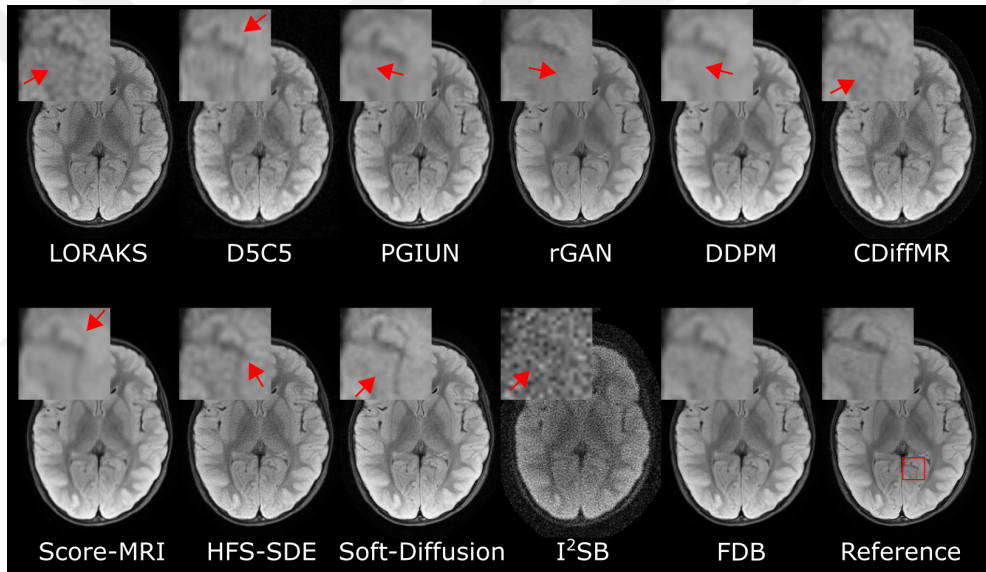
Within-domain reconstructions of representative cross-sections from a FLAIR acquisition in fastMRI at $R = 8$. Images from competing methods are displayed along with the reference image computed via Fourier reconstruction of fully-sampled data. Zoom-in windows are included to highlight differences among methods, and the red box on the reference image marks the zoomed region. In this example FDB has PSNR 30.4dB and SSIM 96.3% while Soft-Diffusion, which is the second best performing method has PSNR 24.9dB and SSIM 93.2%.
